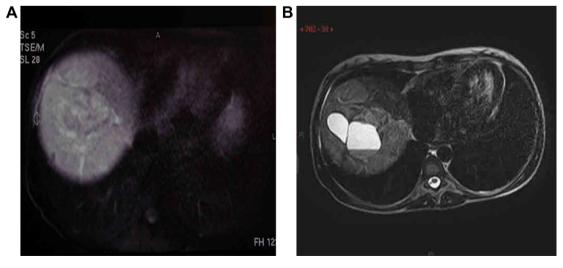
T2-weighted axial MRI of the upper abdomen performed before starting tamoxifen showing a large focal area between liver segments VII and VIII (A); axial MRI, performed after 12 months of tamoxifen treatment, revealing a significant reduction of the largest lesion with an enlarged liquid central area (B). [This figure appears in colour on the web].
